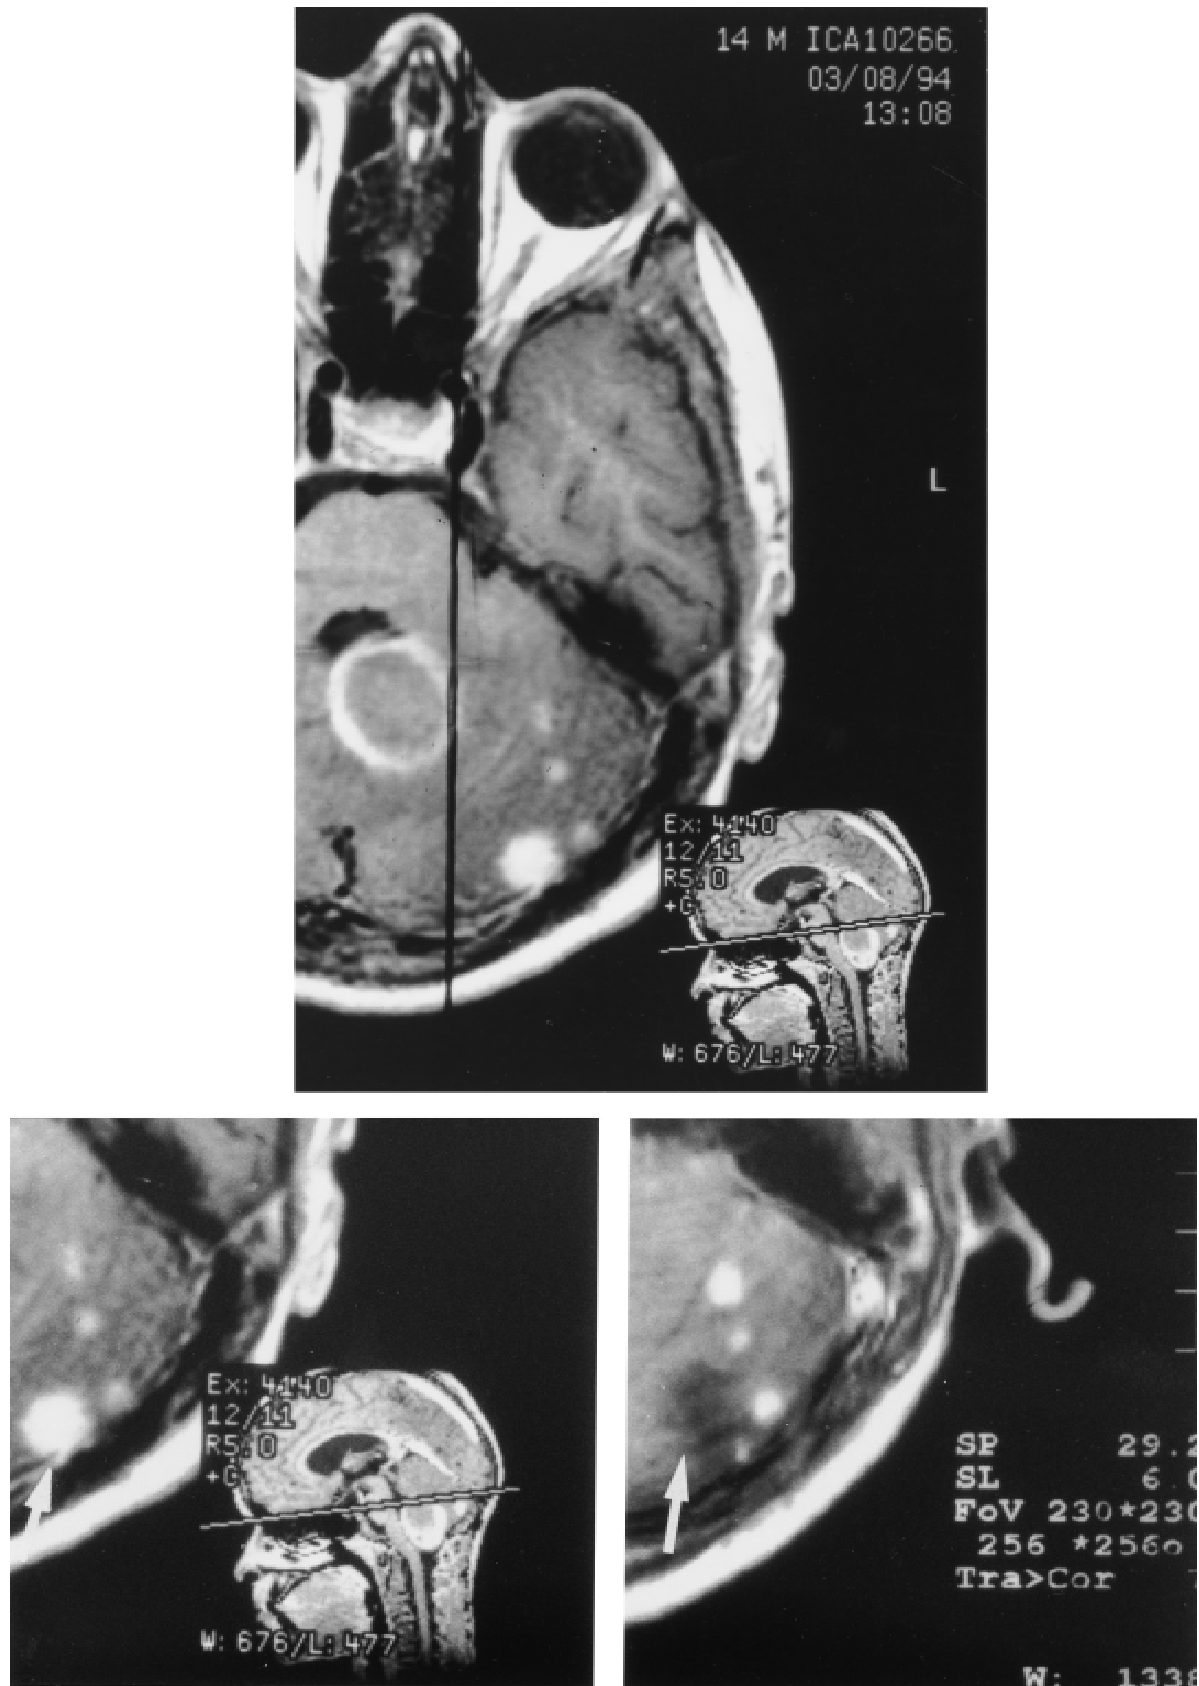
Axial MRI of patient with multiple metachronous hemangioblastomas. Top: The presentation situation before surgery to the largest midline lesion. Bottom: The efficacy of radiosurgery on one of the persisting cerebellar tumors (arrows) (left: before; right: after).
